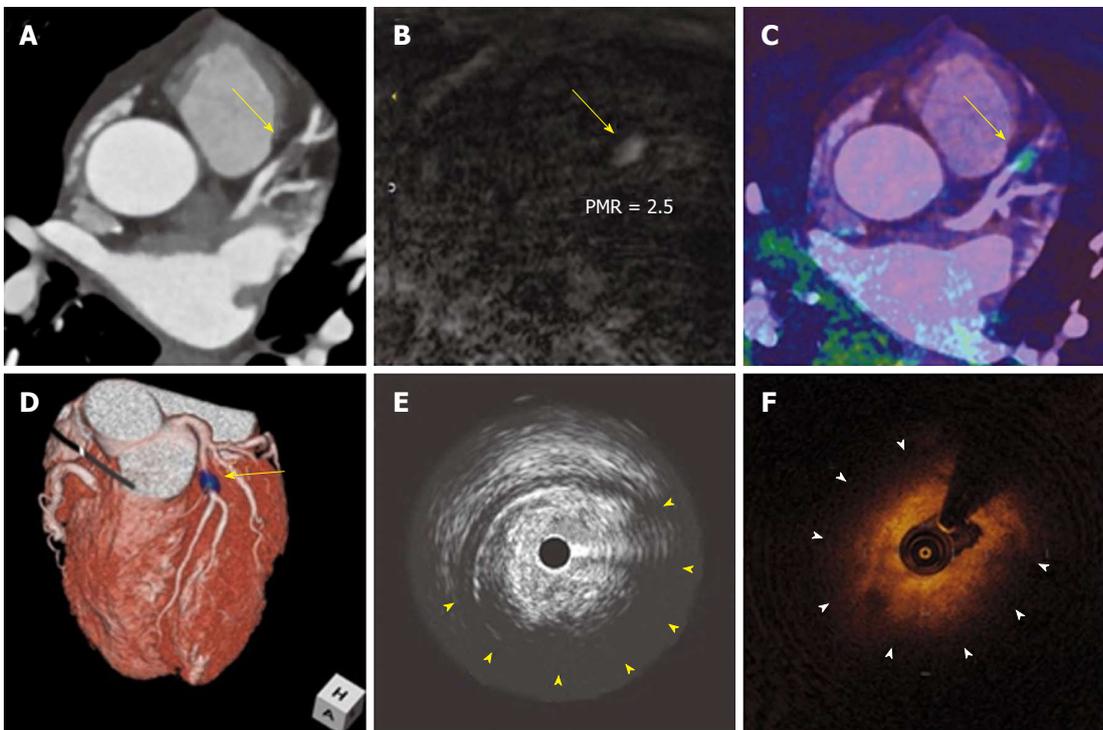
T1 hyperintense coronary plaques in cardiac magnetic resonance. Noninvasive and invasive coronary imaging of a significant plaque in proximal LAD. CCTA (A) showed a noncalcified plaque in LAD causing significant stenosis. When noncontrast T1-weighted CMR imaging was performed (B) a hyperintense lesion was detected. Afterwards, CMR images were fused with CCTA (C and D) and this lesion was found to correspond with the previously described coronary stenosis. Interestingly, during the subsequent coronary angiography it showed a large lipid component in IVUS (E) as well as OCT (F). Adapted with permission from Asaumi *et al*^[106]. LAD: Left anterior descending coronary artery; CCTA: Coronary computed tomography; CMR: Cardiac magnetic resonance; IVUS: Intravascular ultrasound; OCT: Optical coherence tomography; PMR: Plaque to myocardium signal intensity ratio.
